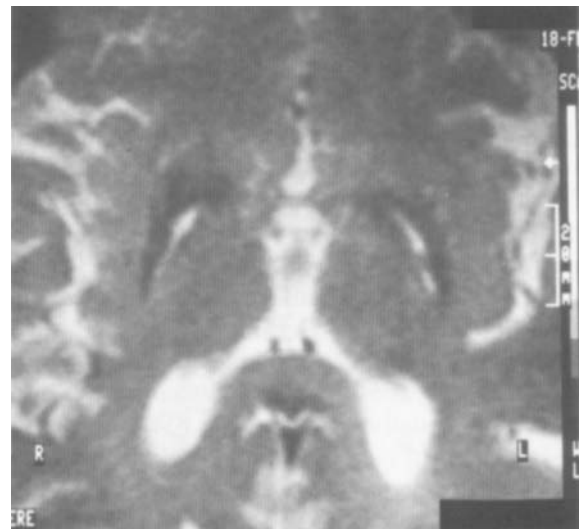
Case 4. Spin-echo T2 MRI sequences in the AP/CL plane demonstrating lesions of the external globus pallidus.
